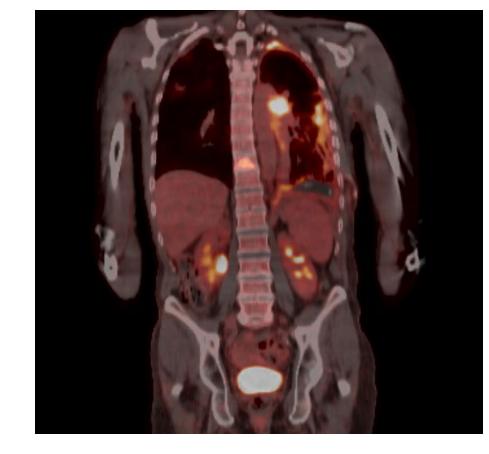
PET scan showing the Left suprahilar mass with moderate FDG uptake. Also showed Hypermetabolic left pleural nodularity and T10 metastasis.
